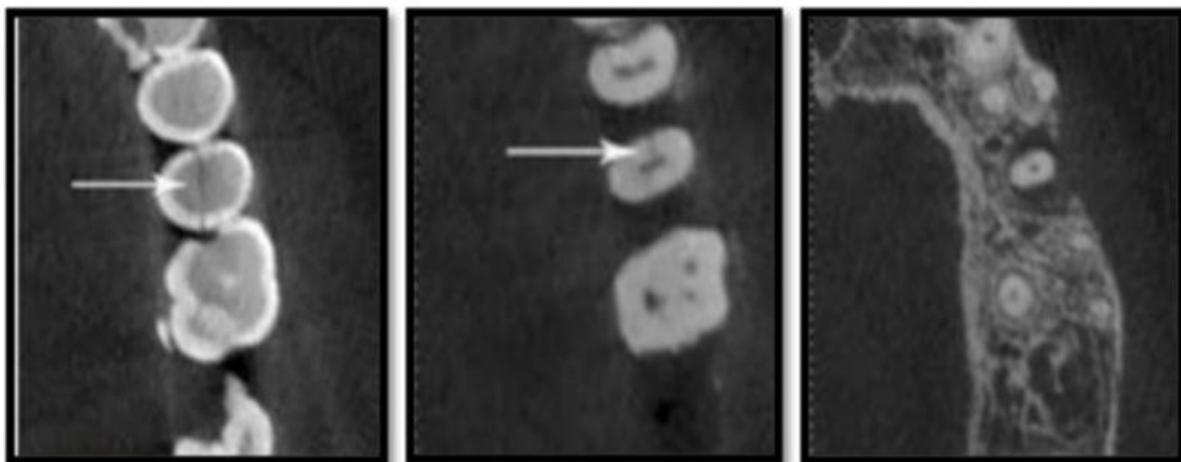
(a,b) CBCT evaluation revealed thin linear cracked line in coronal part of 27 tooth along the mesiodistal tooth surface which was extending to the pulp but cracked line was not extended below the CEJ of tooth. c) Cracked line favour the prognosis as it is not extended below the CEJ of tooth.[17]
